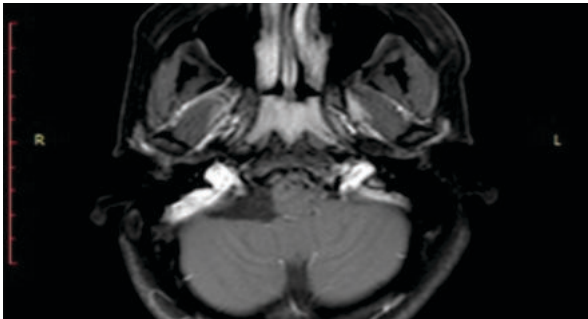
a) Axial T1-weighted MRI shows an arachnoid cyst with signal intensity similar to that of CSF.
